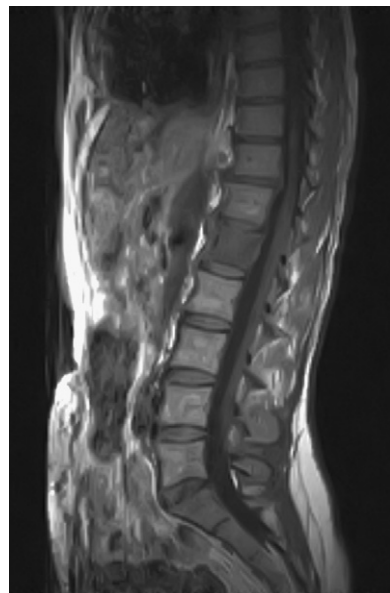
Case 3: 58-year-old female with known history of leiomyosarcoma who presented with L1 signal changes on surveillance image (MRI obtained) and who wished to proceed with oncologic resection. Preoperative sagittal T1-weighted MRI without gadolinium. Lesion did not enhance with gadolinium administration.
